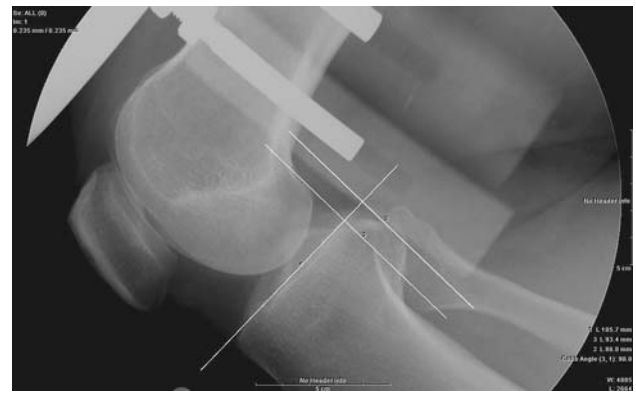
The radiograph shows measurement of posterior tibial translation in 90° flexion. Three lines are drawn: a line across the tibial plateau and perpendicular lines tangential to the midpoint between the most posterior contours of the medial and lateral femoral condyles and tibial plateaus. The distance between femoral and tibial vertical midpoint lines is calculated to determine tibial translation of the knee.
